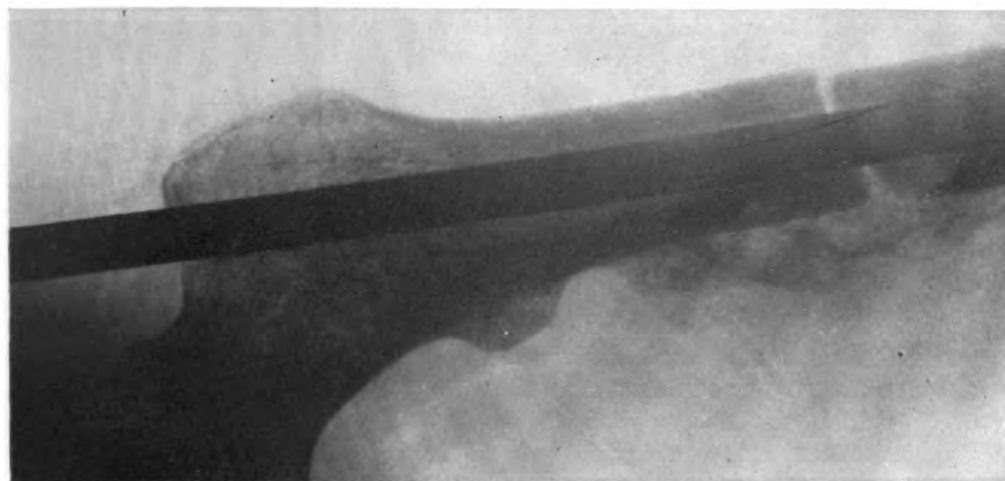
Case 1. Postoperative anterior-posterior x-ray.
